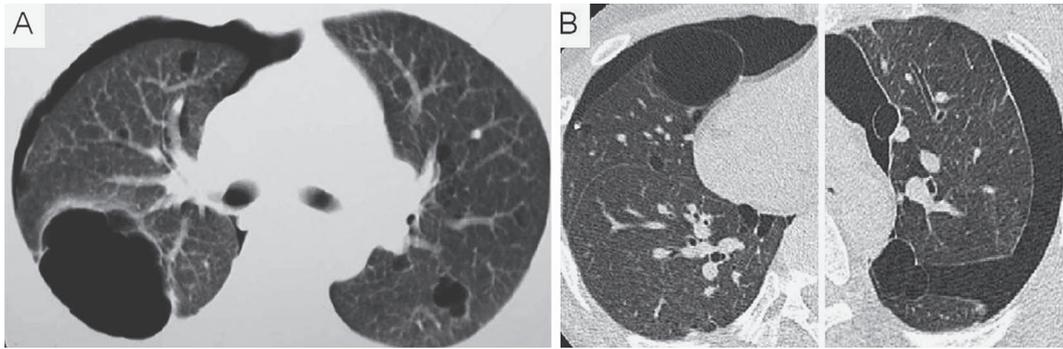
Computed tomography depicts multiple irregularly shaped cysts with a bilateral, basal, and peripheral distribution in the patients' lungs. Scans from (A) the 44-year-old index case in February 1992 and (B) her 32-year-old son in April 2008.
